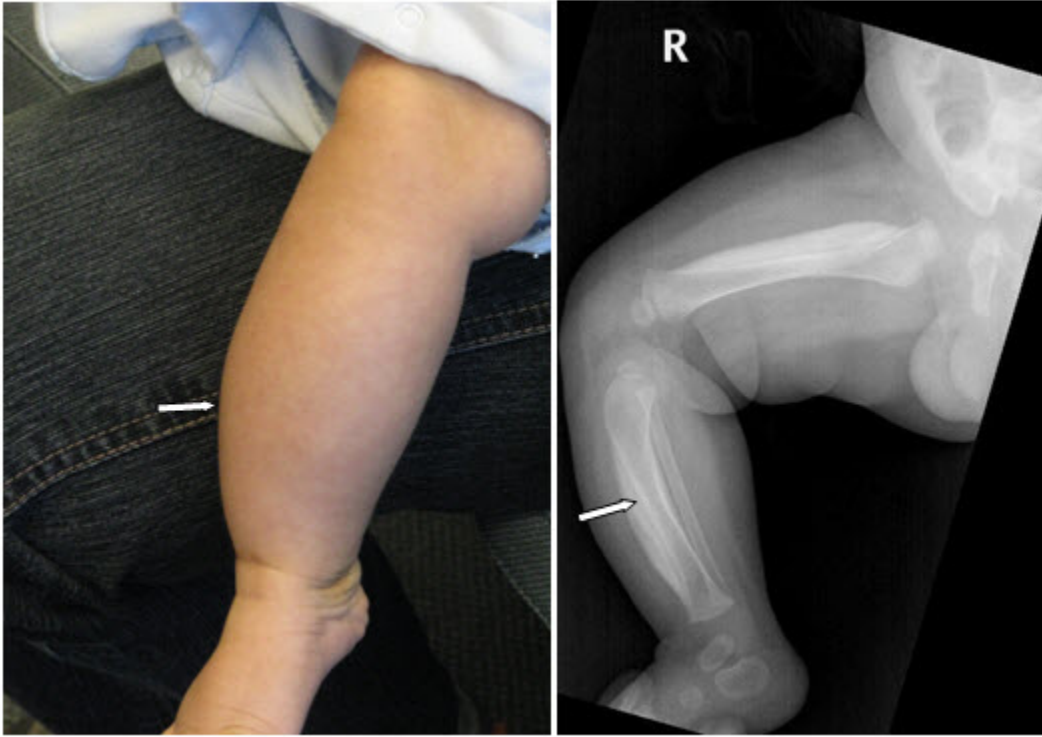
Clinical photograph and radiograph of male age two months with *COL1A1* pathogenic variant p.Arg1014Cys who presented with irritability and swelling over the right tibia
